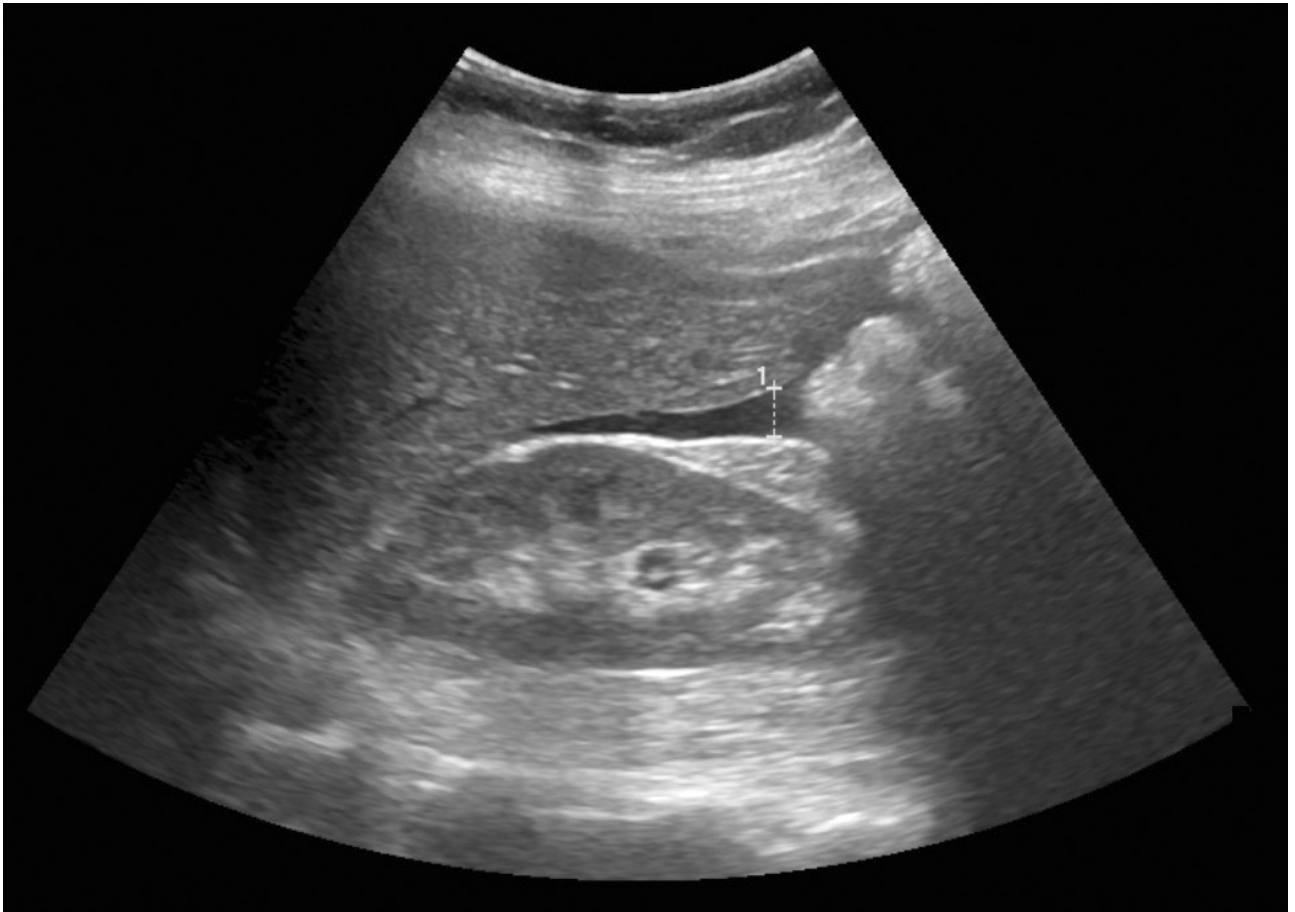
Abdominal ultrasound showing peri-hepatic fluid
